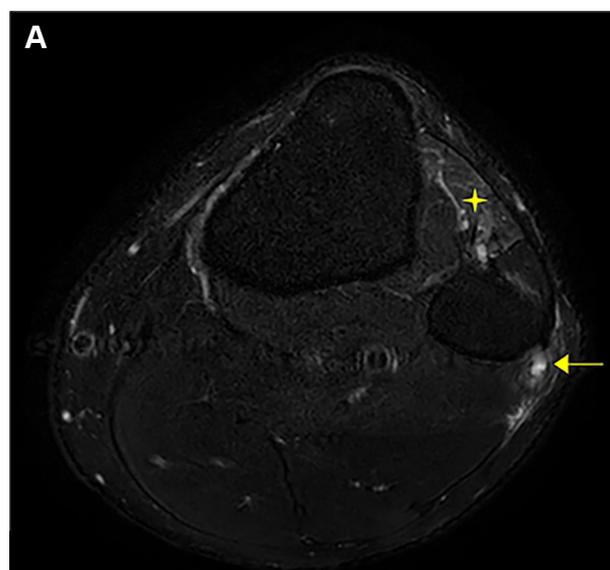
Initial magnetic resonance images obtained at presentation. (A) A T2-weighted fast spin echo Dixon axial image demonstrating cystic changes surrounding the common peroneal nerve (arrow) at the level of the peroneal neck with denervation changes to the tibialis anterior muscle belly (asterisk). (B) A T2-weighted turbo spin echo axial image at the level of the superior tibiofibular joint showing subtle contrast within the common peroneal nerve (arrow) and the joint (arrowheads).
